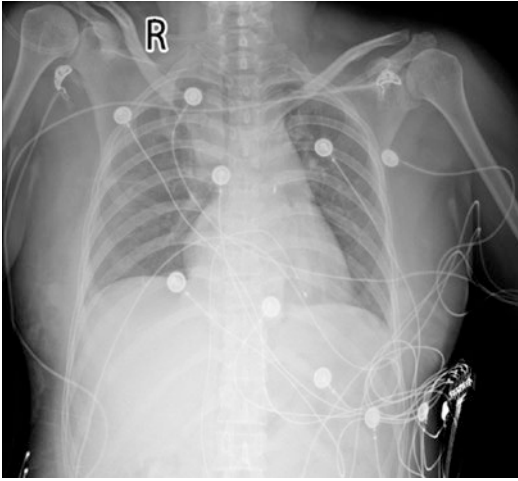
After implantation of IABP and temporary cardiac pacemaker, bedside chest radiograph suggested the thickening of lung texture and signs of pulmonary congestion. X-ray shows IABP catheter and temporary pacemaker electrode. *IABP* intra-aortic balloon pump
